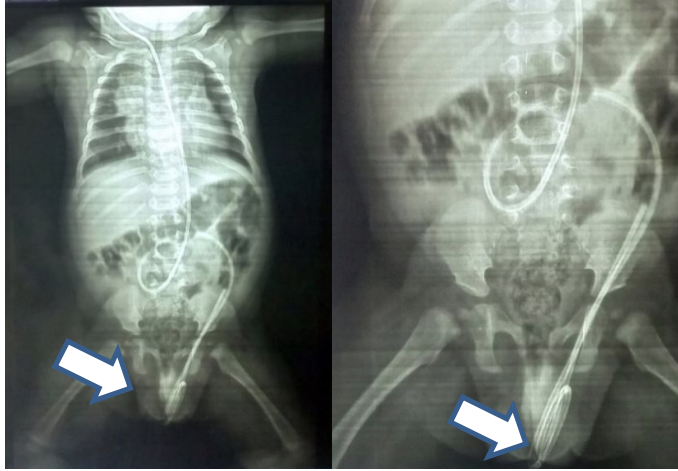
Cervical, thro-pelvic and abdominal X-ray showing left scrotal migration of the drain
